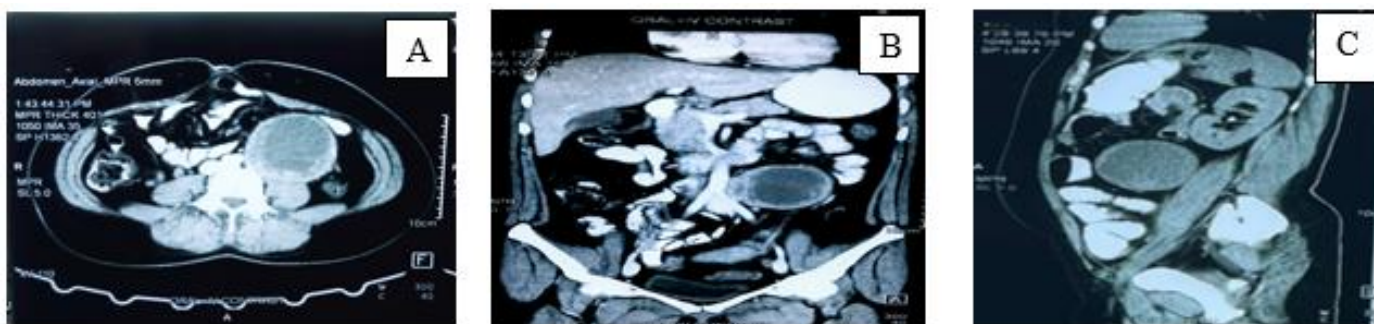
Computed Tomography (CT) of the abdomen in Axial (A), Coronal (B) and Sagittal (C) sections. A large lobulated heterogeneously enhancing soft tissue density mass lesion noted at left mid abdomen, abutting the aorta and mildly compressing the left mid ureter.
